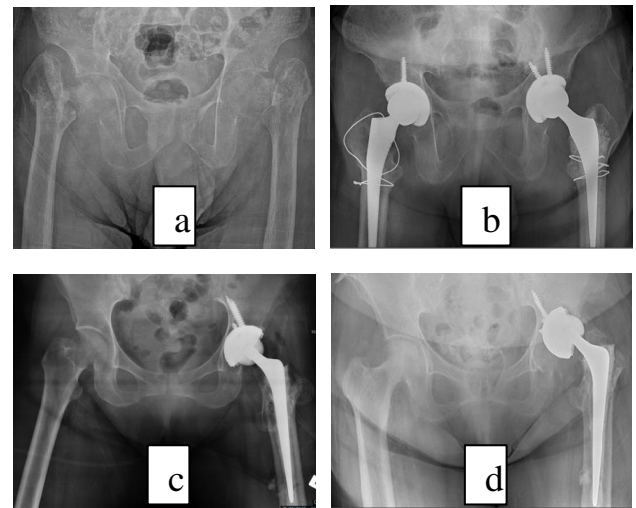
X-rays of Mr. T: Pre parathyroidectomy (a) and post THR (b), Mrs. Z: normal parathyroid level (c) and hyperparathyroidism (d)
